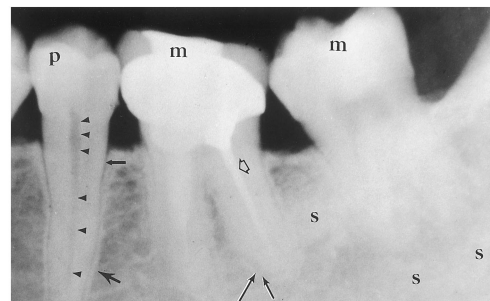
Periapical (dental) radiograph of the mandibular premolar (*p*) and two molars (*m*). The premolar has a normal lucent pulp chamber (*arrowheads*), lucent periodontal ligament (*small solid arrow*), and dense lamina dura (*larger arrow*). There is periapical sclerosis (*S*) around the roots of the molars and widening of the periodontal ligament (*highlighted arrows*). The root canal of the second molar is obliterated. The metallic material in the pulp canals of the first molar is from a root canal procedure (*open arrow*). These findings can also be seen on CT scans.
